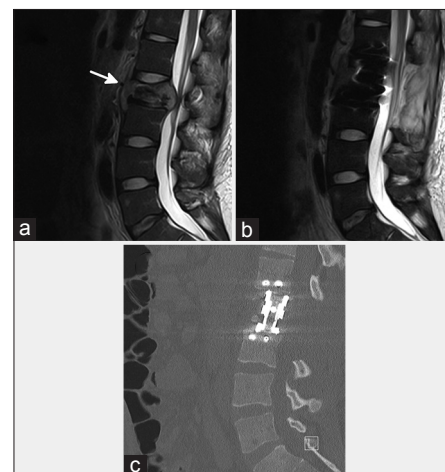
Sagittal magnetic resonance imaging reconstructions show L2 spinal coccidioidomycosis (arrow) at the presentation with severe spinal canal narrowing (a) and after surgical decompression of neural elements (b). Postoperative sagittal computed tomographic reconstruction shows L2 corpectomy (c)
